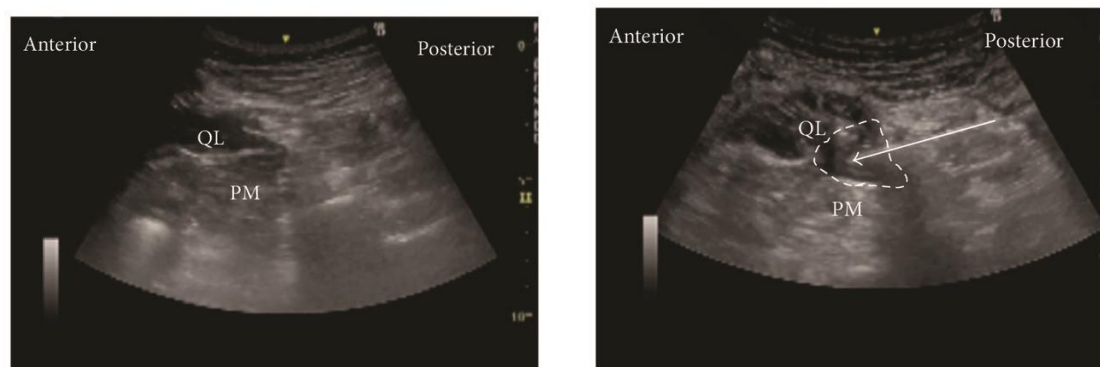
Ultrasound images of anterior QLB. (a) Preinjection and (b) postinjection. QL: quadratus lumborum, PM: psoas muscle, white arrow: needle trajectory, and white dotted line: spread of local anaesthetic.
